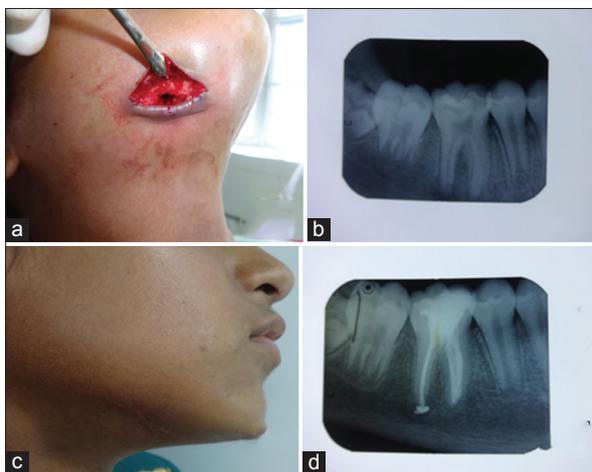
(a) Sinus tract opening visible extraorally, (b) IOPA with periapical radiolucency w.r.t 46, (c) healed scar tissue after 2 months, (d) post-operative IOPA showing healed periapical pathology.
